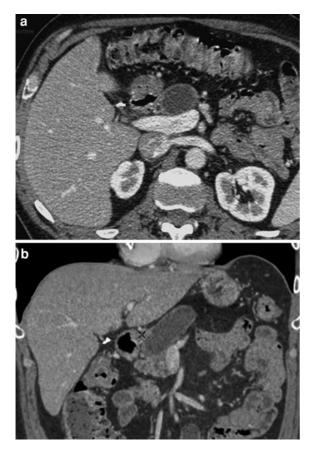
Contrast-enhanced CT after cholecystectomy: normal appearance. Axial view (a) and coronal view (b). Note the metallic clips on the right side of the hepatoduodenal ligament (cystic duct and cystic artery ligation)
